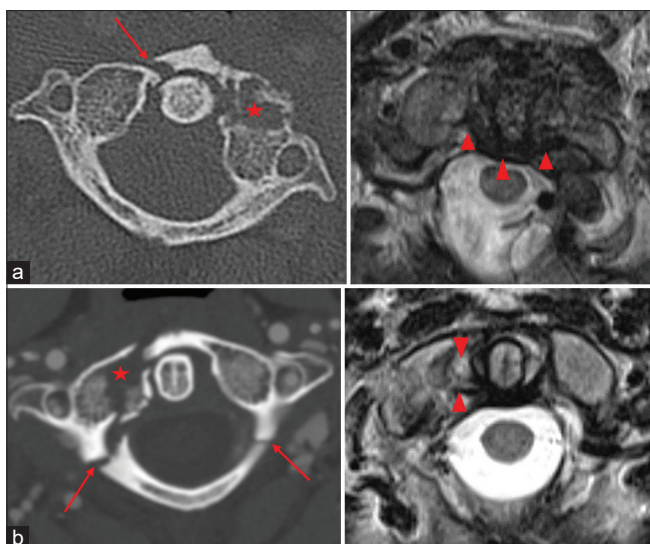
(a) Axial CT of the cervical spine (left) in a 30 year old trauma patient status post MVA demonstrating a right C1 anterior arch fracture (red arrow) and comminuted left C1 lateral mass fracture (red star). Axial T2 weighted MRI (right) in the same patient demonstrates an intact transverse atlantal ligament (red arrowheads). (b). Axial CT of the cervical spine (left) in a 30 year old trauma patient status post MVA demonstrating bilateral C1 posterior arch fractures (red arrows) and comminuted, right C1 lateral mass fracture (red arrowhead). Axial T2 weighted MRI (right) in the same patient demonstrates a torn right transverse atlantal ligament (red arrows). CT - Computed tomography, MRI - Magnetic resonance imaging, MVA - Motor vehicle accident
